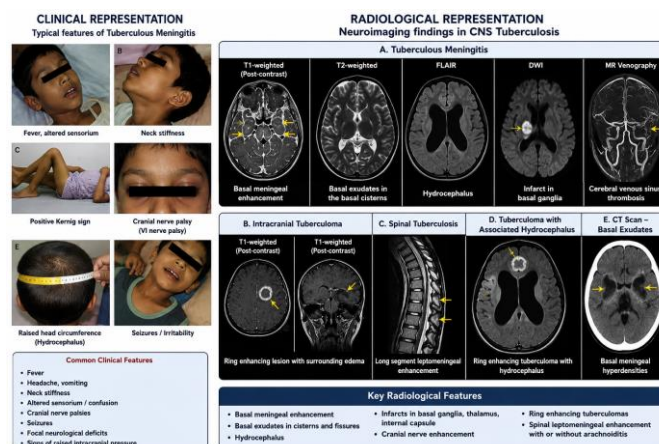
It shows the main clinical and radiological features of central nervous system tuberculosis with special reference to tuberculous meningitis. It points out the typical neurological signs and MRI/CT findings like basal meningeal enhancement, hydrocephalus, infarction, and ring enhancing tuberculomas, which help in diagnosis and evaluation of the disease.
